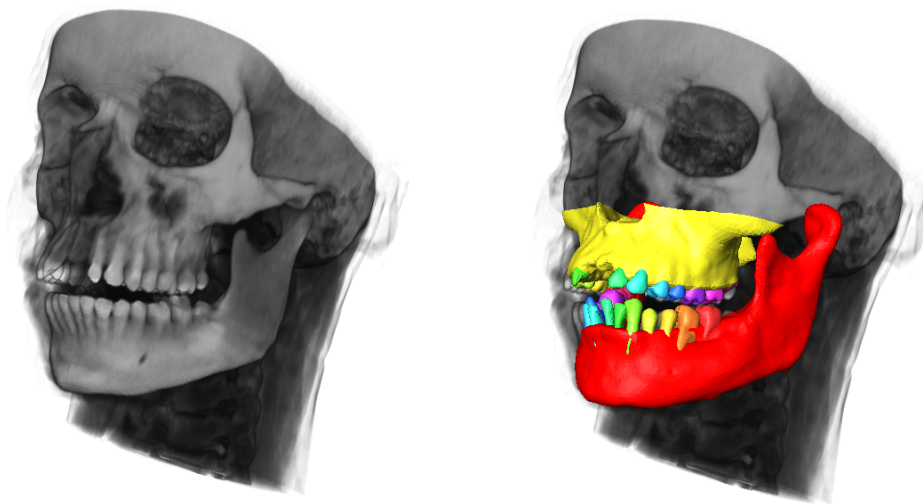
Left: Input of the algorithm is the CT image. Right: Output - segmented jaws (red and yellow) and detected and identified teeth (marked by different color).
